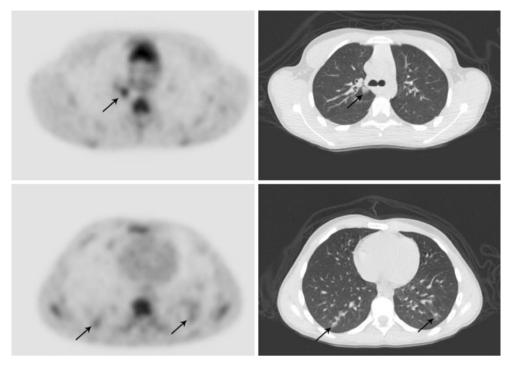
A 14-year-old boy, 13-months S/P completion of therapy for Hodgkin disease, undergoes surveillance imaging with whole-body FDG PET/CT. At the time of imaging, the patient had intercurrent upper respiratory symptoms with intermittent fever, nasal congestion, sore throat and cough. Axial FDG (*left*) and corresponding low-dose CT (*right*) images reveal abnormal FDG-uptake corresponding to
